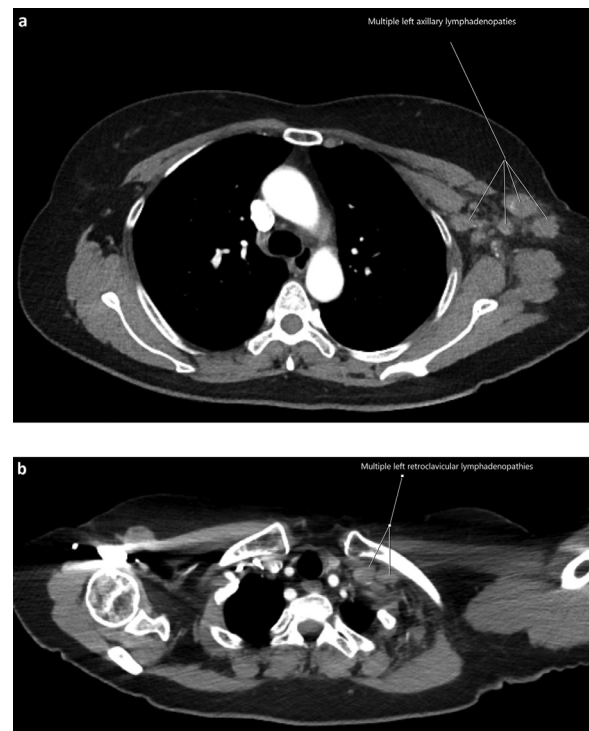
CT thorax with contrast. Multiple enlarged pathologic left axillary nodes (A) and multiple left retroclavicular lymphadenopathies (B). The largest lymph node measured 21 x 15 mm (not shown). No suspicious breast pathology.
